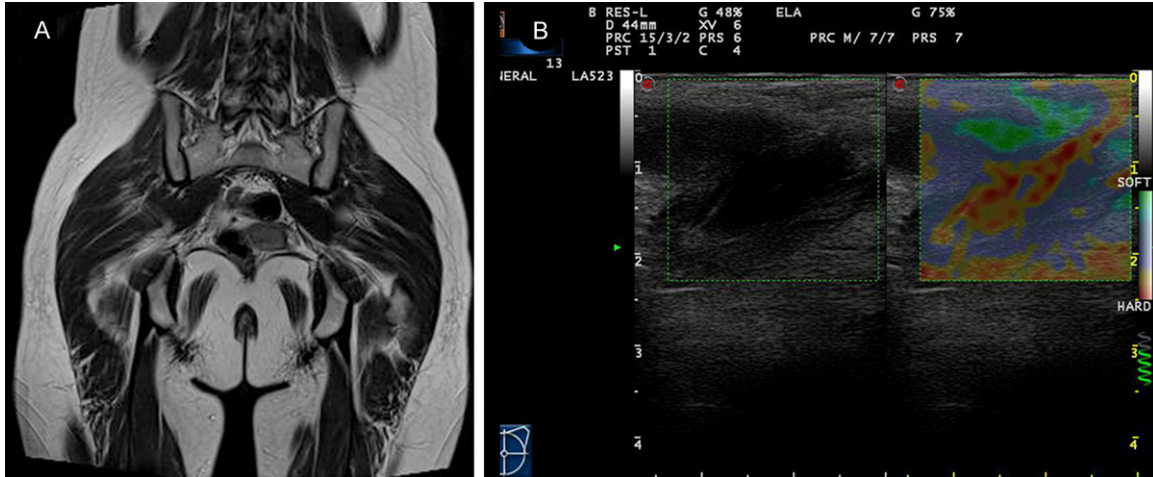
A case of levator ani with no defect detected by MRI (A). ES showed predominantly red and is clearly distinguishable, scored as ES4 (B). The case was control.
